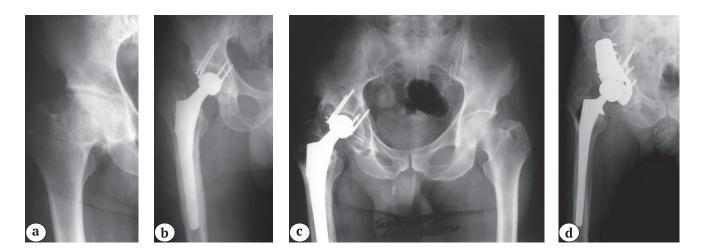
X-rays of male patient 48 y.o.:
